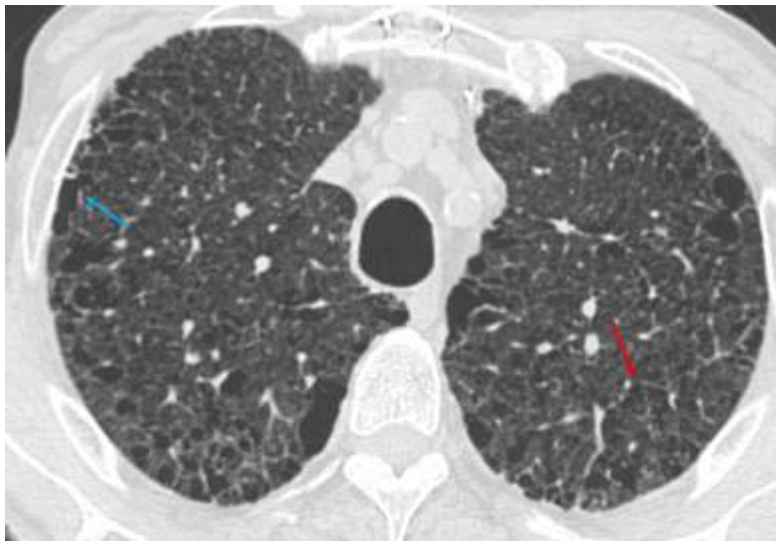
Centrilobular and paraseptal emphysema. Axial CT through the upper lobes shows confluent centrilobular emphysema (blue arrow) and mild paraseptal emphysema (red arrow).
